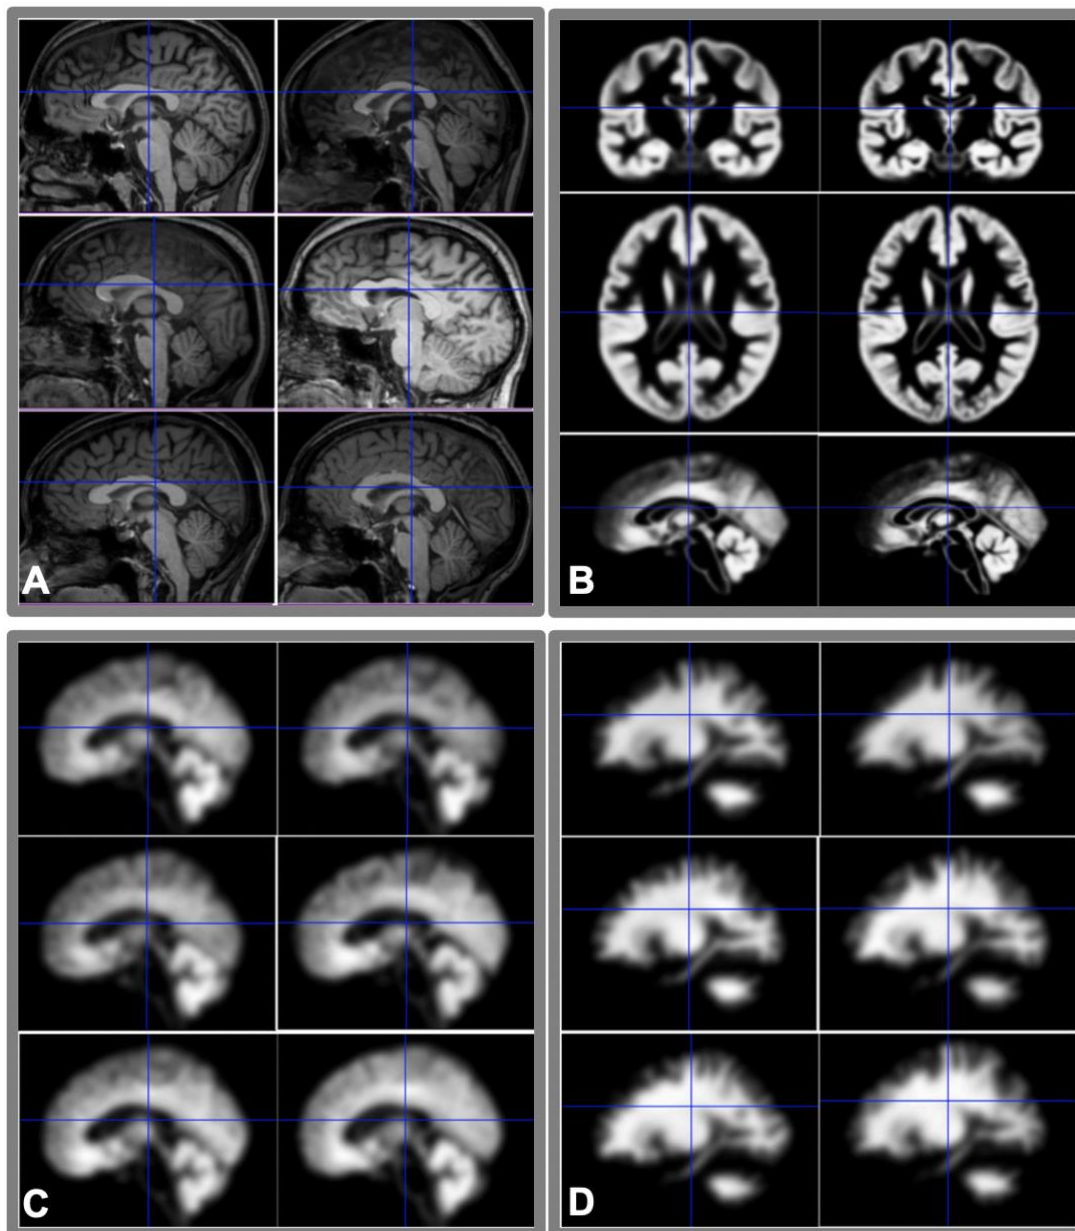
Inter-subject registration is used in VBM8 to place all subjects into the same stereotaxic space. Requires the input of A) T1-weighted images (six participants shown), B) DARTEL template; first iteration template (left) and final iteration template (right), to output modulated, smoothed and normalized C) gray matter and D) white matter and CSF (not pictured).
